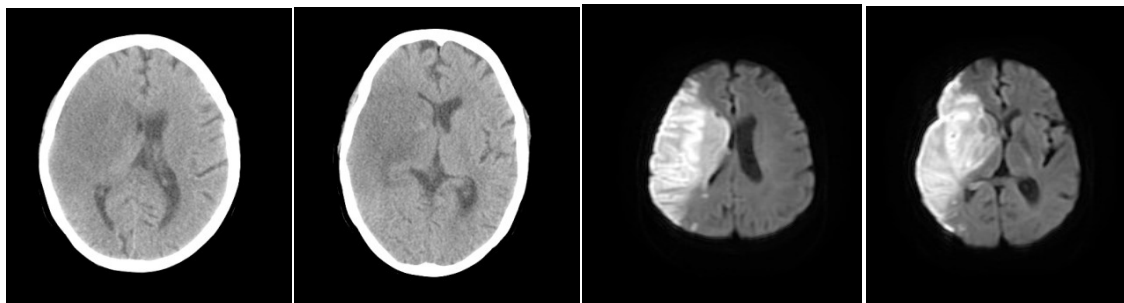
NCCT and MRI-DWI brain image shows same ASPECT score in same patient with subtle hypodensity in NCCT and restriction in DWI with involvement of internal capsule, lentiform nucleus, insular cortex, M1, M2, M3, M4, M5 and M6 in MCA artery distribution in a patient of hemiparesis
